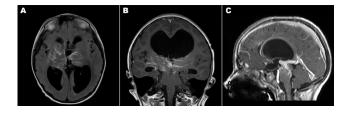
A) Axial B) coronal and C) sagittal T1 MRI with gadolinium demonstrating extensive, bilateral arteriovenous malformation within basal ganglia, thalami and midbrain, and obstructive hydrocephalus.
